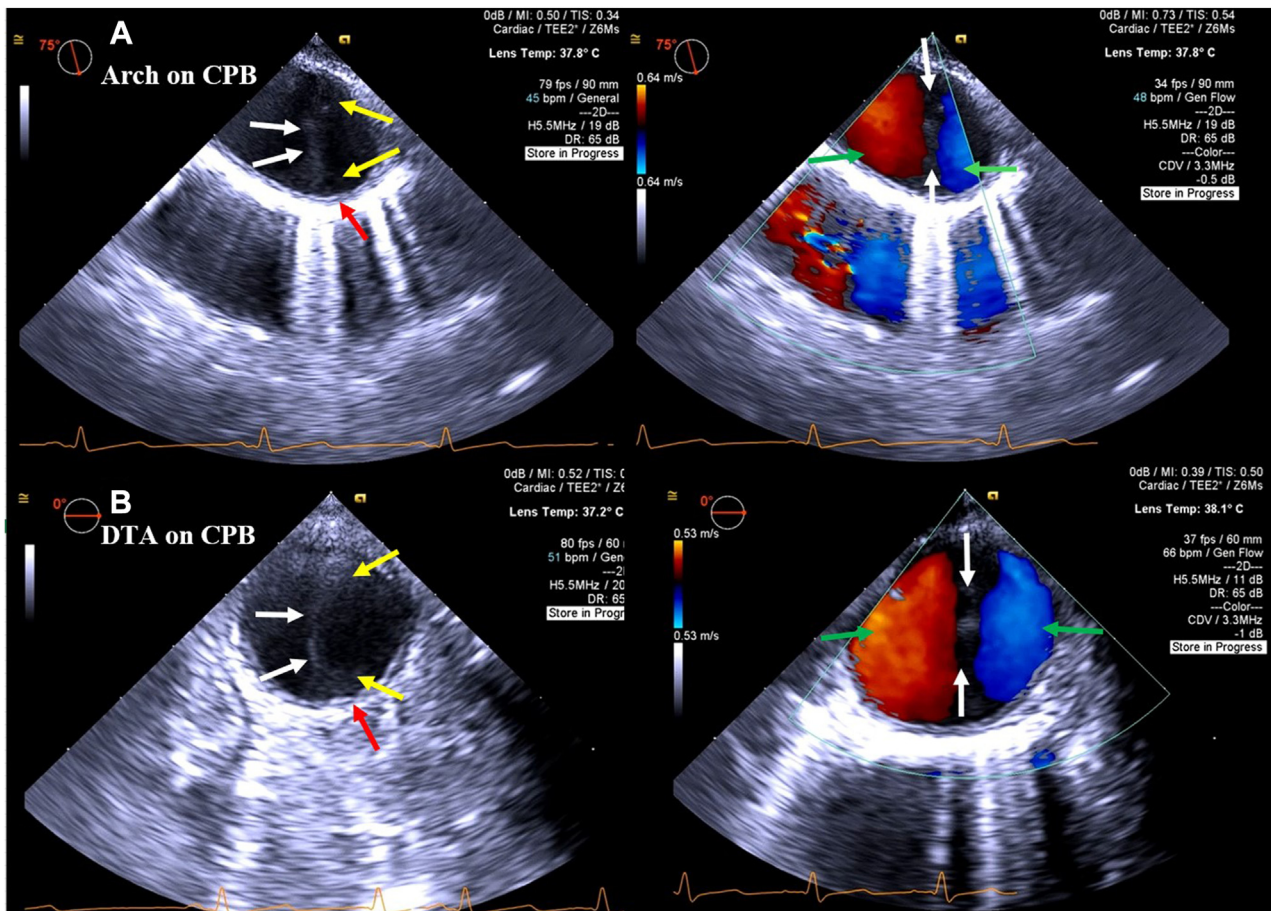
Two-dimensional TEE, upper esophageal distal aortic arch short axis (A) and midesophageal DTA short-axis (B) views during CPB without (left) and with (right) color flow Doppler, demonstrates spontaneous echocardiographic contrast resembling an intimal dissection flap (*white arrows*) dividing the aorta into two lumens (*green arrows*). The hypoechoic appearance of the spontaneous echocardiographic contrast relative to the intima (*red arrow*), poorly demarcated borders, and dispersion features (*yellow arrows*) help differentiate this from a true intimal dissection flap.
